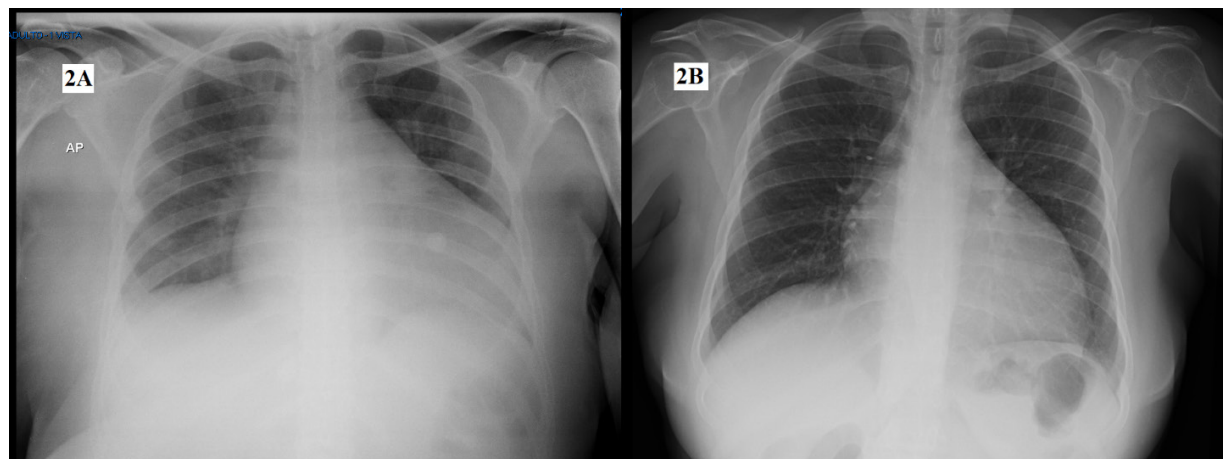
A) Chest radiography of hospital admission. B) Chest radiography after hormone therapy.
